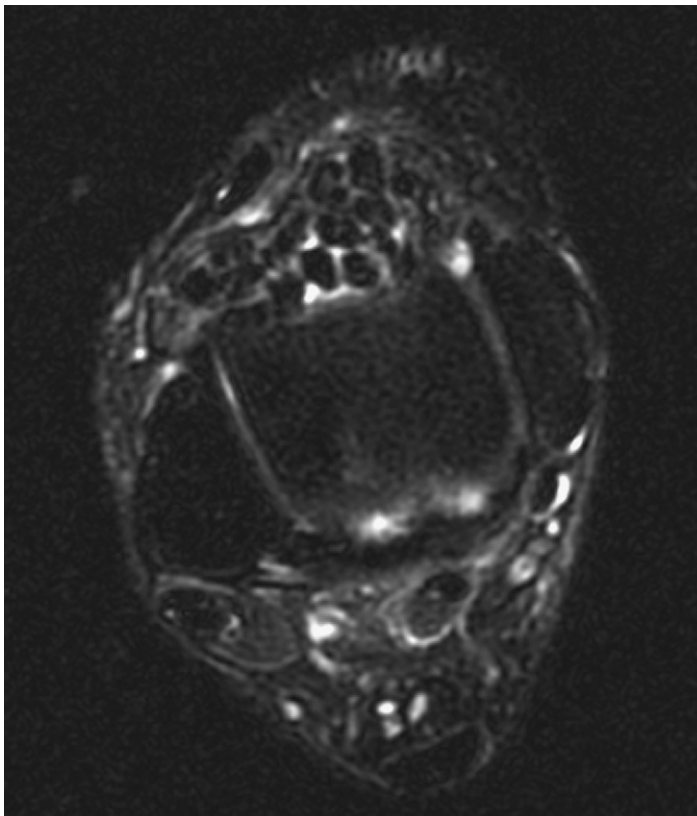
T2-weighted fast spin echo (FSE) axial magnetic resonance image scan showing multiple osteocartilaginous bodies, diffuse low-intensity areas similar to that seen on the T1-weighted images.
